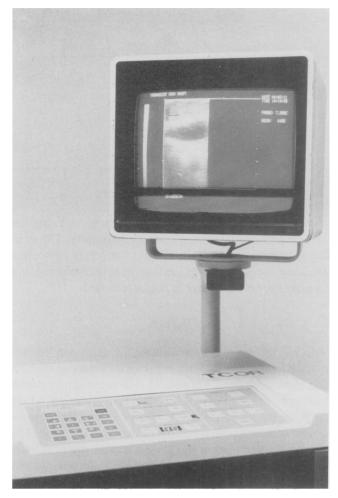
Intraoperative ultrasound machine. Although conventional ultrasound equipment can be used, a specially produced unit was used for this study. This machine has single touch controls that can be easily covered by a sterile sheath.
